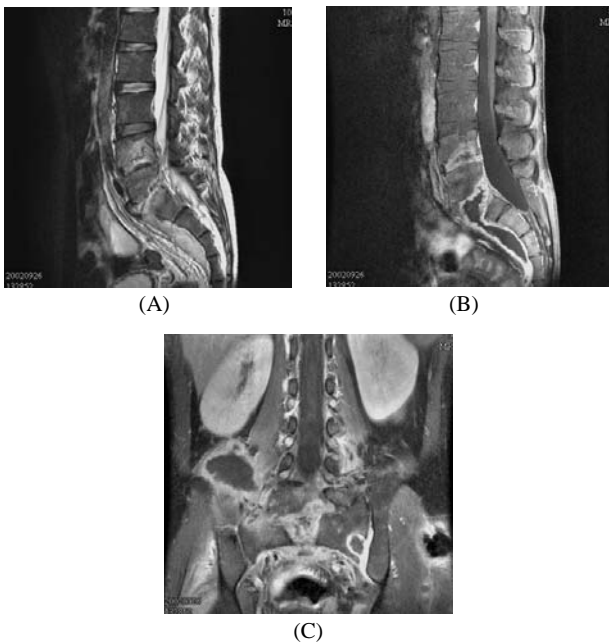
(A) T2-weighted sagittal MRI revealing extensive L4/5 and L5/S1 spondylodiscal destruction and (B) strongly enhanced peripheral ring after injection of gadolinium of the well-demarcated presacral abscess. (C) Coronal MRI revealed abscess formation over right psoas muscle, left sacroiliac joint and left thigh.
